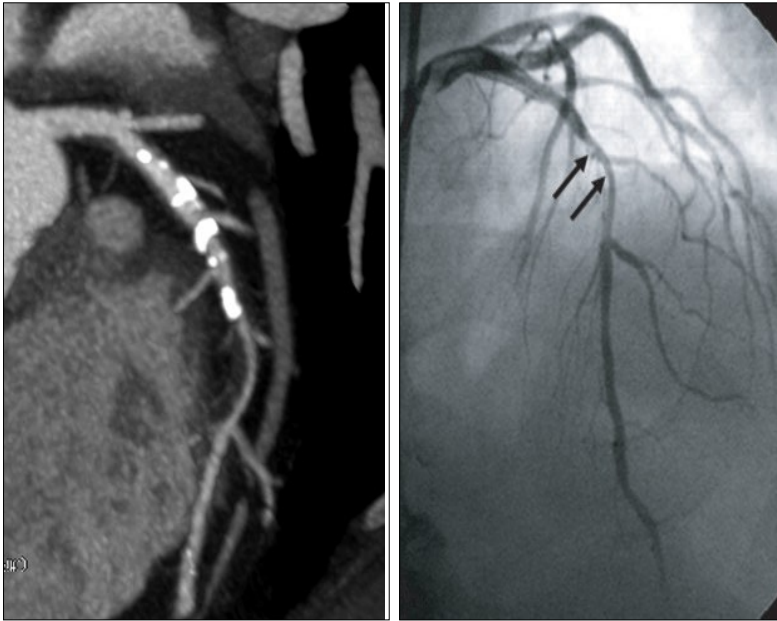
Coronary CT angiography versus coronary angiography finding (3)
